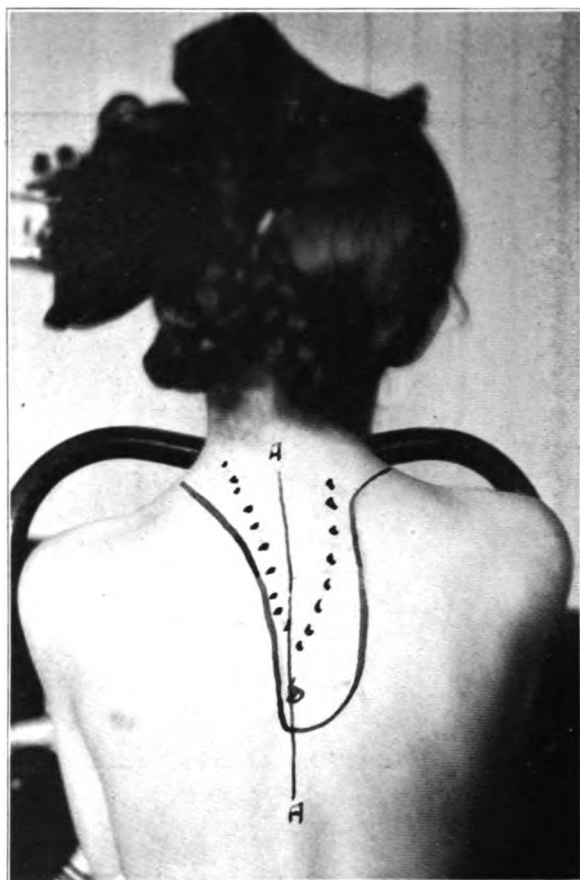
A A, line of vertebral spines. Continuous line includes area of bronchial gland dulness. Dotted line shows area over which whispered bronchophony was heard. For x-ray picture, see Figure 16.
